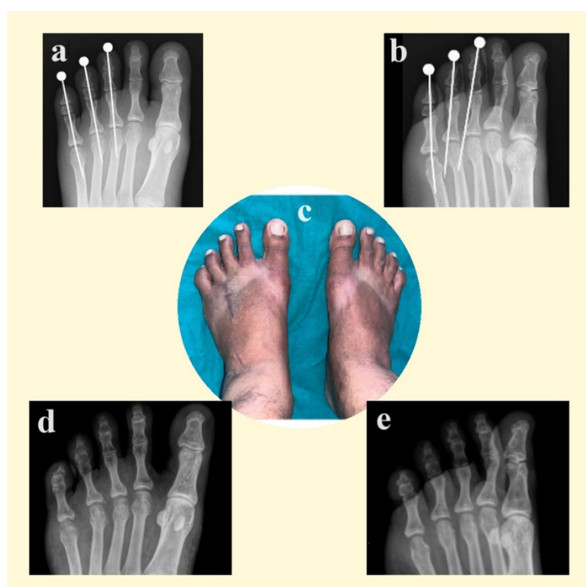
Post-operative radiographs (a) Anterior-posterior, (b) Oblique view, (c) Clinical picture after 1 year follow-up, (d) and (e) Radiographs after 1 year follow-up anterior-posterior and oblique views respectively.
